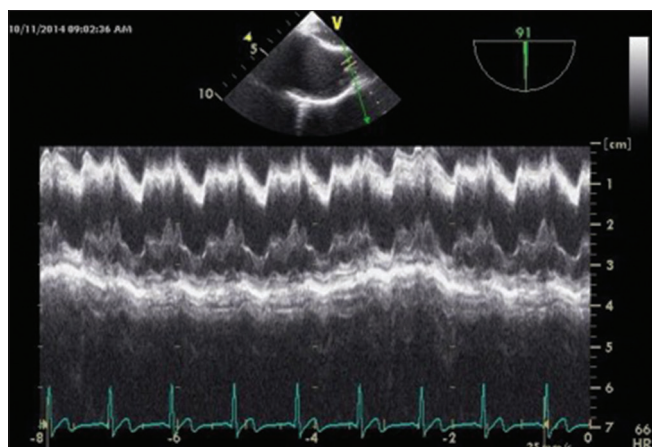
Transesophageal echocardiography image of the midesophageal bicaval view in anatomical M-mode showing the trace of superior vena cava diameter over a respiratory cycle
